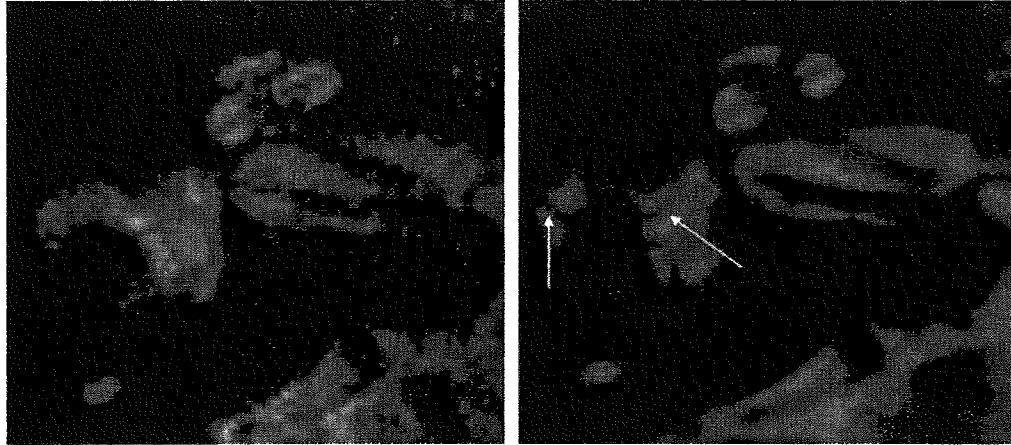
Images of a normal subject. High spatial resolution T2-weighted image at 3 Tesla. Spatial resolution is  $0.3 \times 0.3 \times 0.5$  mm. The left image was obtained with a 3D-turbo spin-echo sequence and the right image was obtained with 3D-CISS. On 3D-CISS, band-like artifacts (arrows) are prominent because of magnetic field inhomogeneity, and the vestibule appears deformed.
